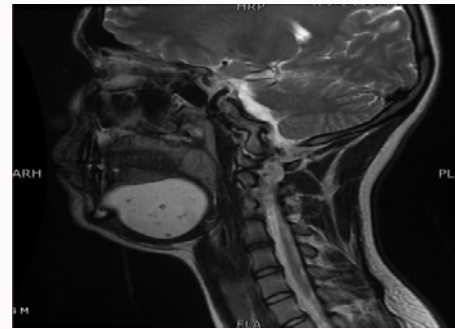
MRI scan (T2-weighted imaging) shows cystic lesion with high signal intensity. Within the lesion there are some low intensity structures, maximum diameter 5.7 cm x 4.4 cm.
